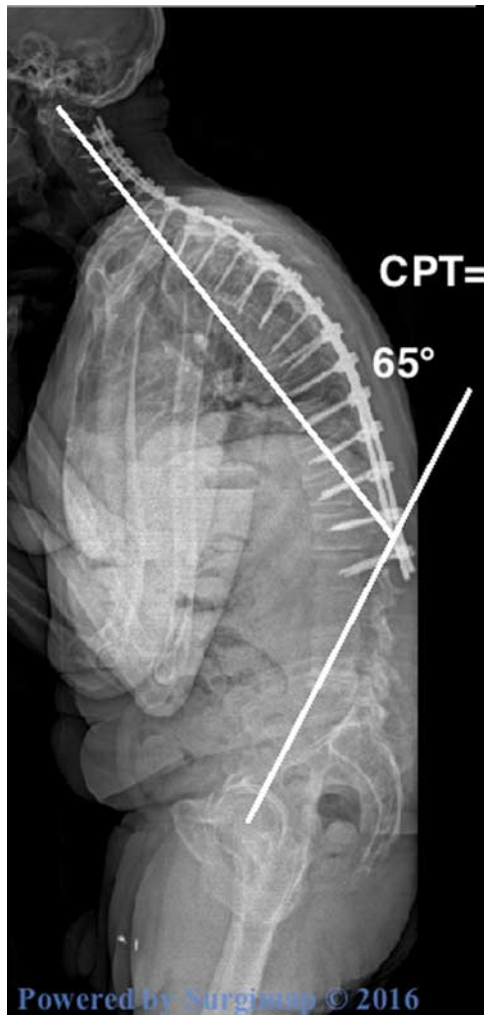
Index surgery postoperative radiographs demonstrating substantial residual cervical deformity and spinopelvic deformity that is simultaneously captured by C2 pelvic tilt (CPT).
